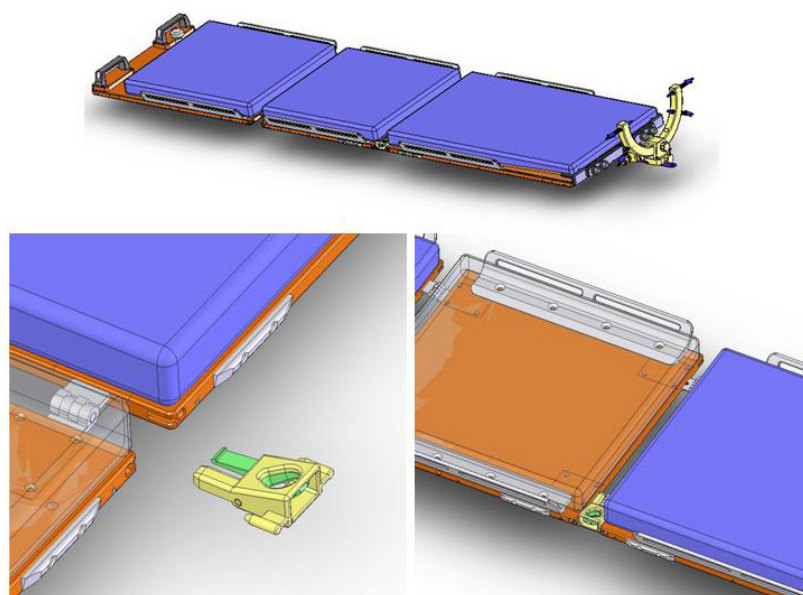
The newly developed fully functional MR-compatible *flexible* operating table has a special MR-compatible tabletop, which is divided into 3 parts. When the surgeon wishes to take a MR image, the tabletop is placed in a flat position and a spacer is inserted into each of the 2 tabletop joints. The spacers tightly lock the 3 parts of the tabletop together.
